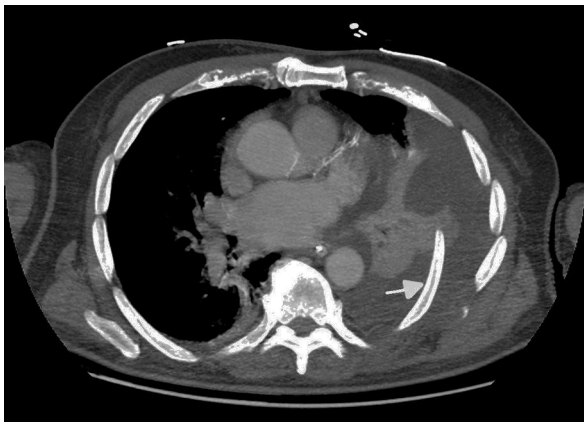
Cross-sectional slice from the chest computed tomography, showing a segment of the left rib piercing the lung (arrow) with associated hemothorax.
